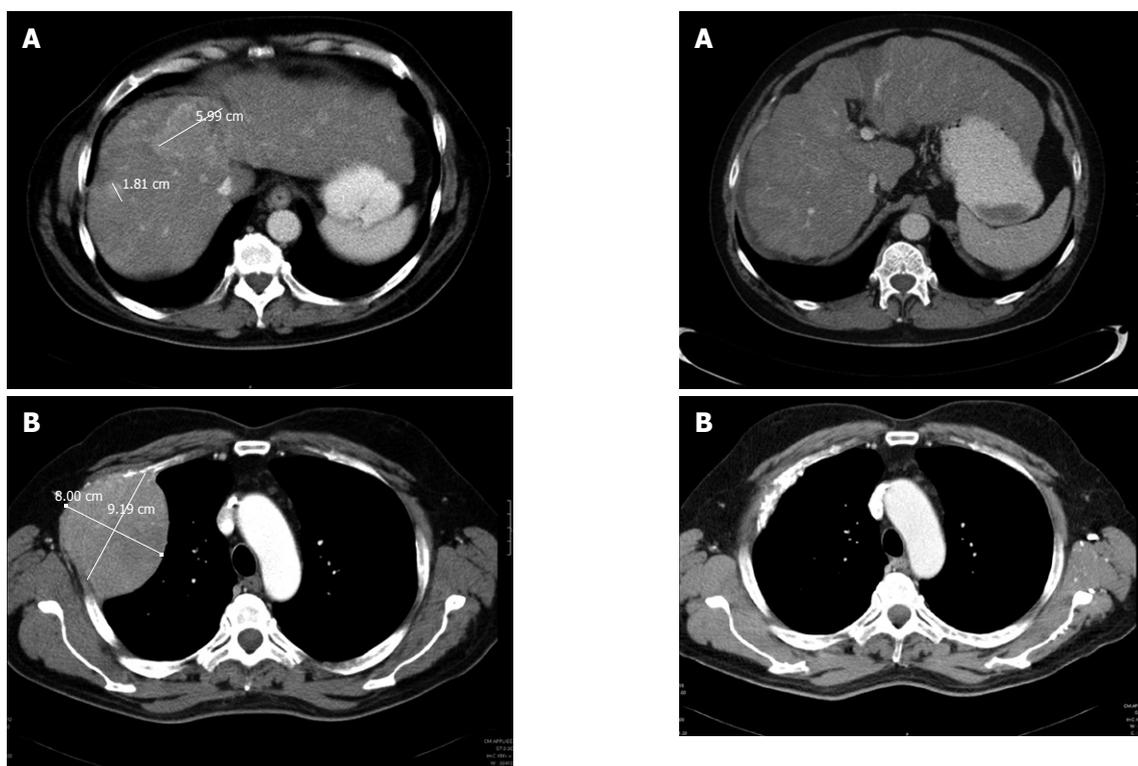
Radiologic assessment of the primary liver tumors and the thoracic metastasis before initiation of sorafenib therapy in September 2007. A: Multiple hepatocellular carcinoma lesions (maximum diameter 6 cm) in computed tomography scan of the liver; B: Thoracic metastasis of the 2nd rib (maximum diameter 8.00 cm \times 9.19 cm).
